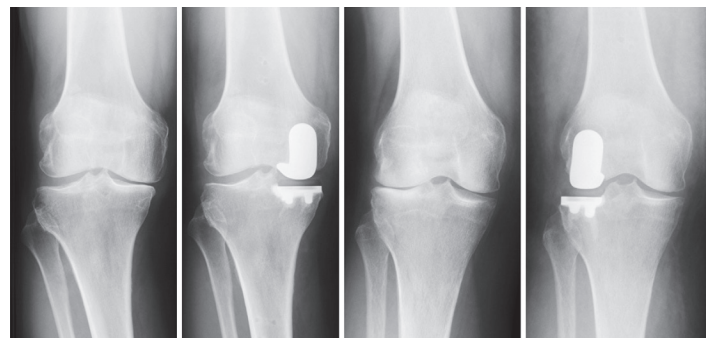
Preoperative and postoperative radiographs of: medial Mako Partial Knee (left), and lateral Mako Partial Knee (right).³³
